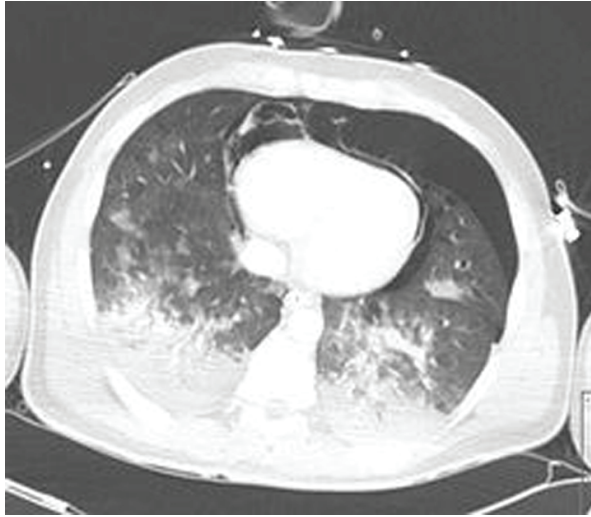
CT scan of the chest showing massive hemothorax, pneumothorax, and pneumopericardium.
